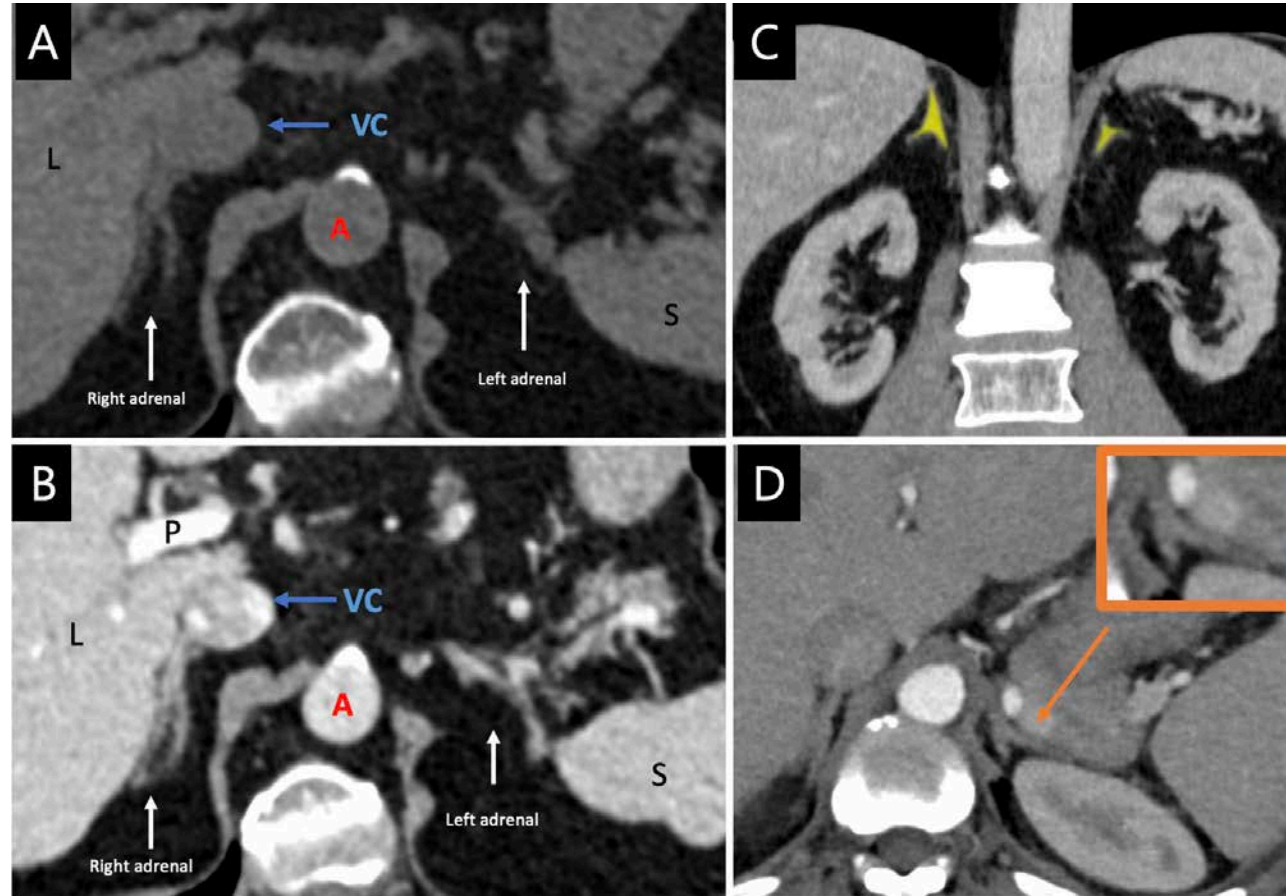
Axial (A and B) CT images obtained in the same patient without (A) and with contrast administration (B). Liver (L), spleen (S), aorta (A). Coronal (C) and axial (D) images in a different patient. On the coronal image, the adrenal glands are rendered in yellow.
